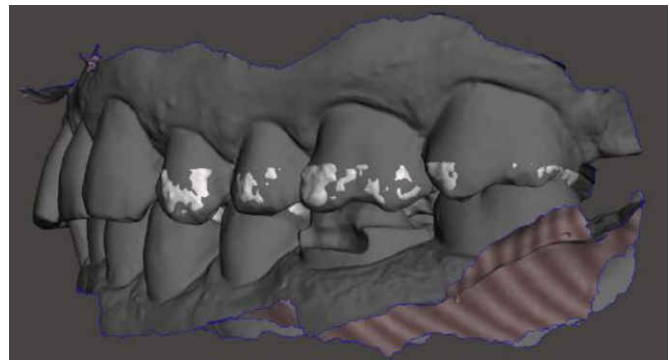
Overlay of the two data sets in Meshmixer. The scan data is shown in dark grey, the X-ray data in light grey.
